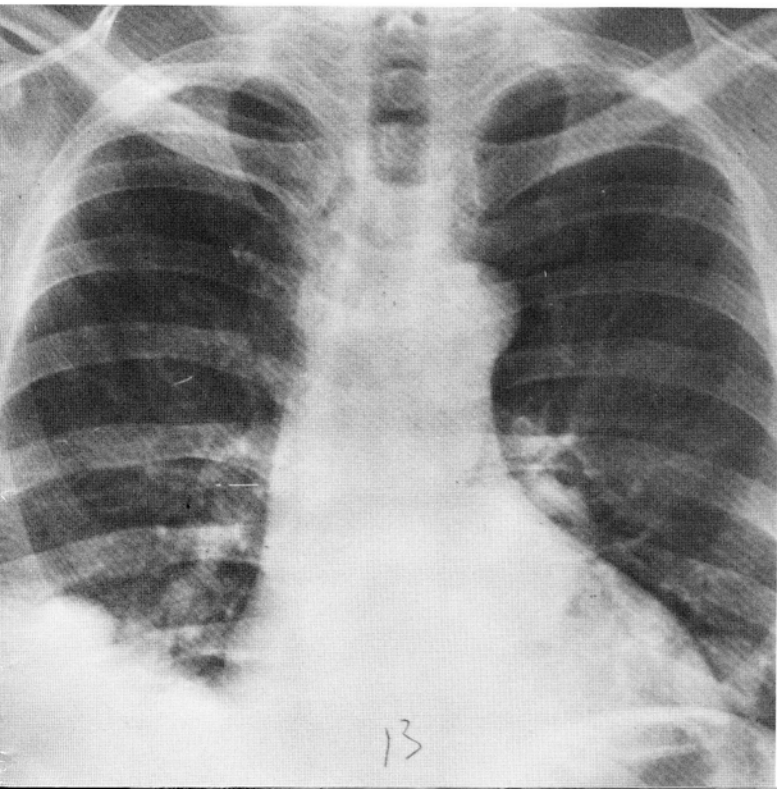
Roentgenogram taken in July 1958 showing large pulmonary nodules.
